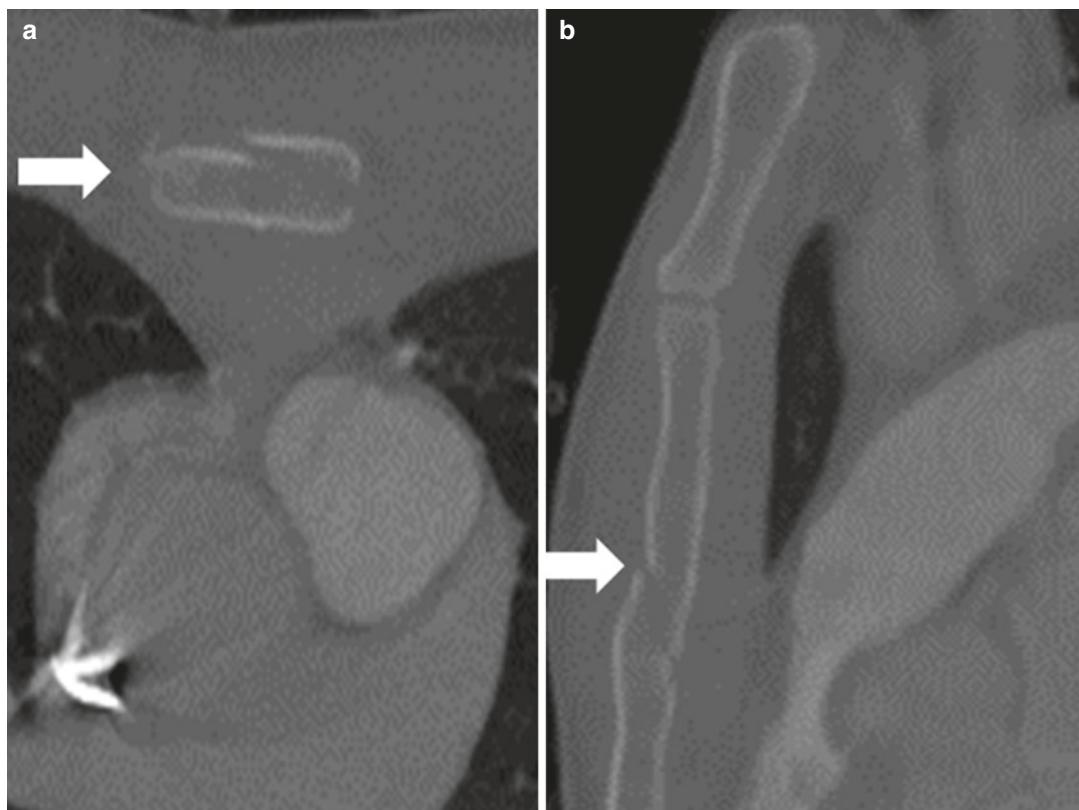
Fifty-year-old man presenting after MVC. Axial (a) and sagittal (b) IV contrast-enhanced CT images of the sternum in bone windows show a mildly displaced sternal body fracture (arrows)
